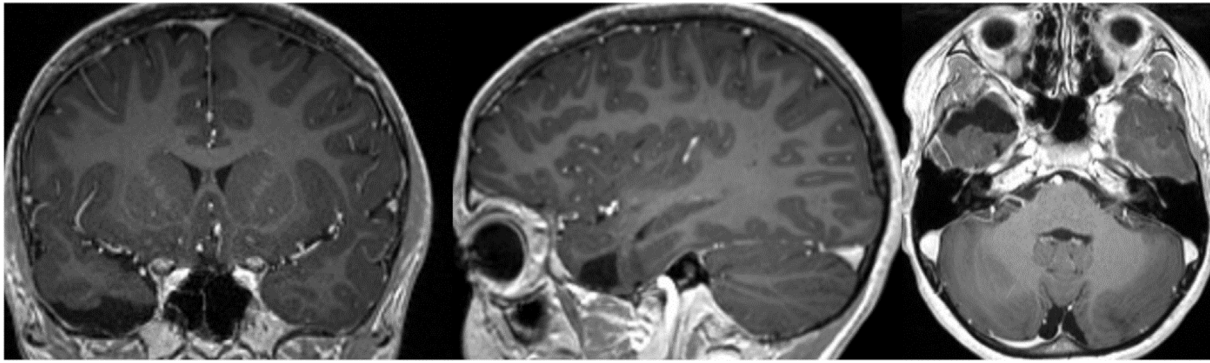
Brain MRI post-contrast images status post selective resection of the anterior temporal lobe tumor.
